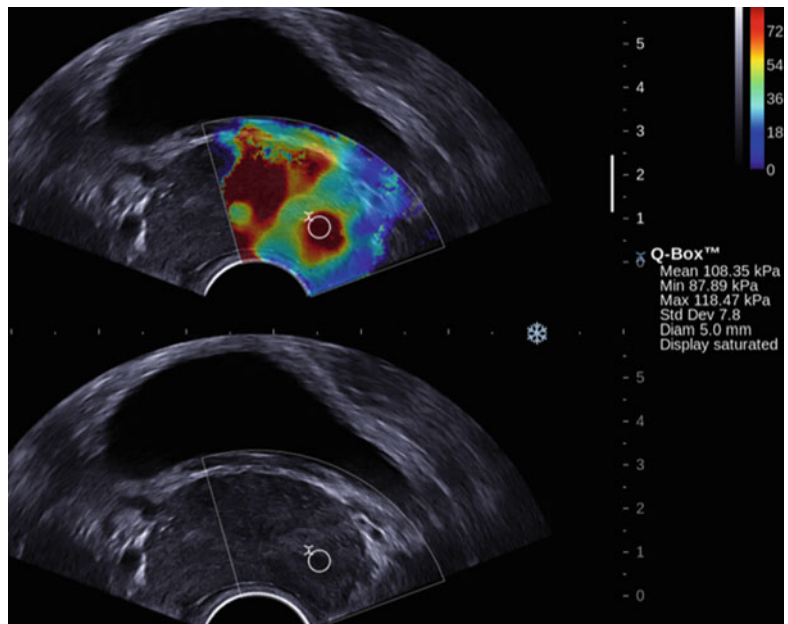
True positive for Gleason 6 carcinoma. This patient presented with a low PSA but firm left side on digital rectal exam. B-mode imaging and color Doppler produced no findings. Shear wave elastography presented this image. Note the posterior high stiffness lesion on the left side. This lesion read at a high stiffness (119 kPa) and was confirmed on biopsy to be a Gleason 6 carcinoma
